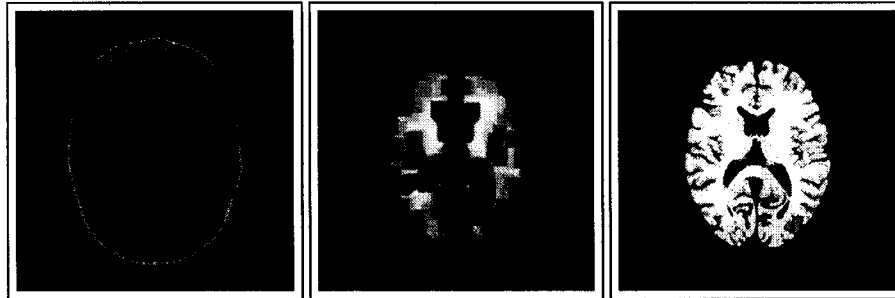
Example of opening by reconstruction of an MR image. Left: original image. Middle: eroded image. Right: final image, after reconstruction and subsequent thresholding. The original image is used as the control image in the reconstruction.
